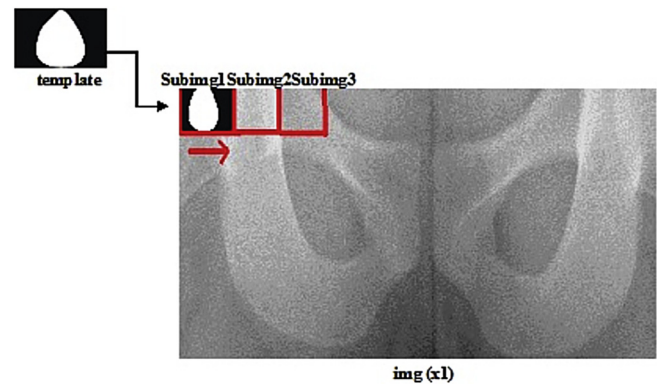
Identifying the starting reference point (center of mass of the obturator foramen). Note that, first, a hand-drawn template is designed in AutoCAD. Then, it is operated on the hip radiograph (x1) to detect similarities between the sub-images and this is used to decide the most similar sub-image to the template image as the obturator foramen. Then, the center of mass of the obturator foramen is identified.
